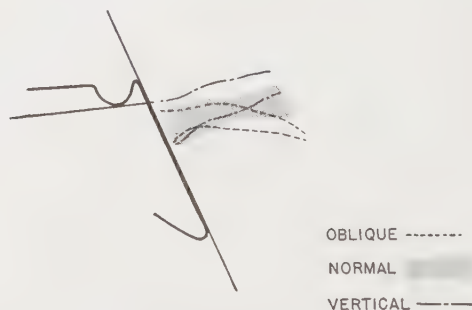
The ranges of petrous crest position in normal and artificially deformed skulls are shown in superimposed tracings of roentgenograms registered on the clivus and on a line tangent to the lower border of the sella turcica. Note that the medial ends (anterior) of the crest are virtually identical in range in both of the deformed types and in the normal. The lateral (posterior) ends of the crest have an elevated range in the Vertical type of deformation and a depressed range in the Oblique type, both in relation to each other and to the normal sample.
